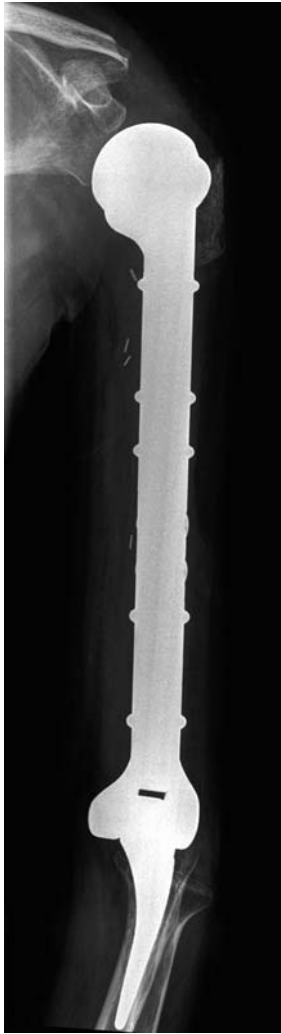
Radiographic follow-up 6 months after surgery of a total humerus replacement (patient no. 2): a bony ingrowth of the transposed acromion/clavicle onto the Trevira tube is shown
